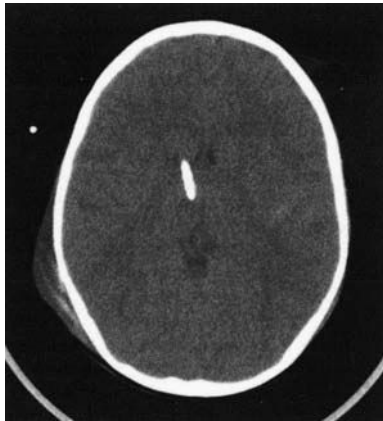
Axial unenhanced head CT scan demonstrating a malpositioned EVD in the right thalamus that required reinsertion.
